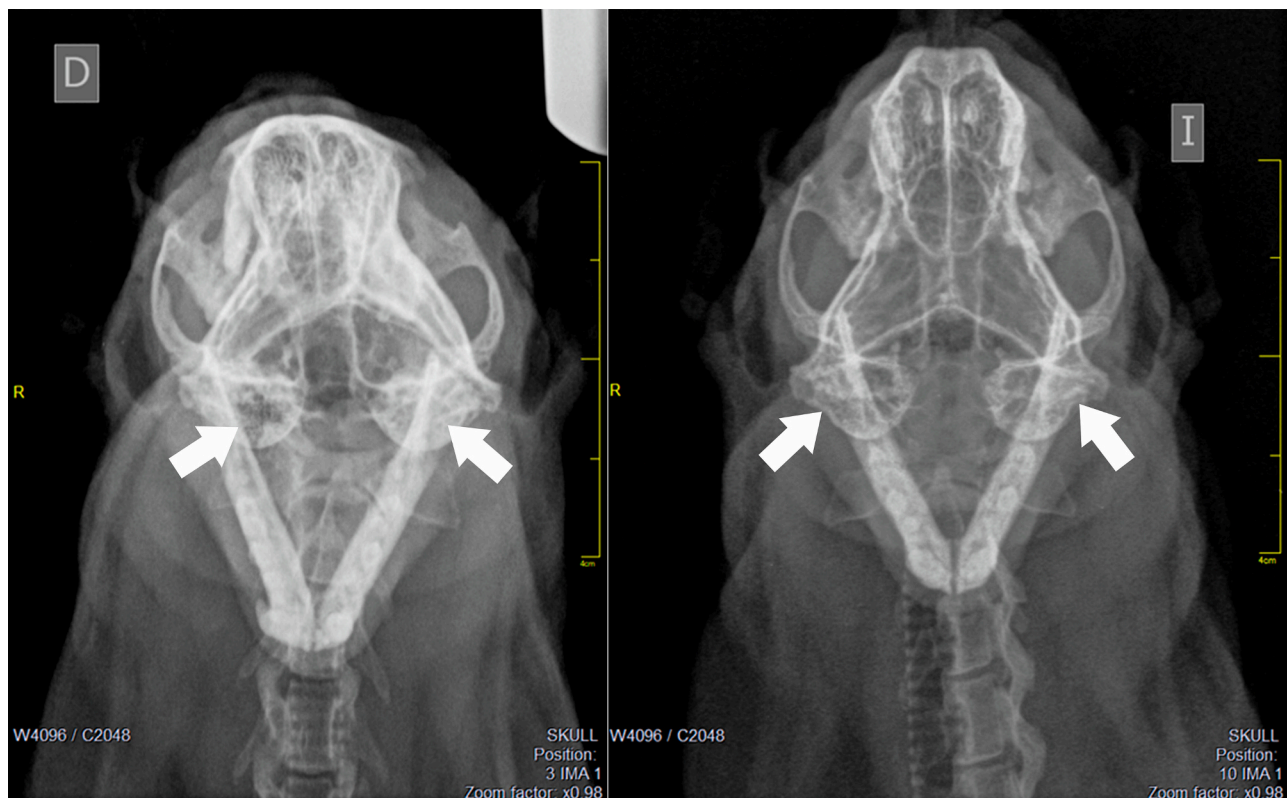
Radiographs of the head including before (left) and after (right) antibiotic treatment. Bulla tympanica of each radiograph is marked (arrows).
